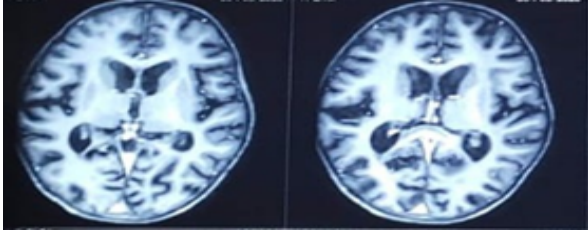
multiple tuberculomas on MRI (magnetic resonance imaging)
